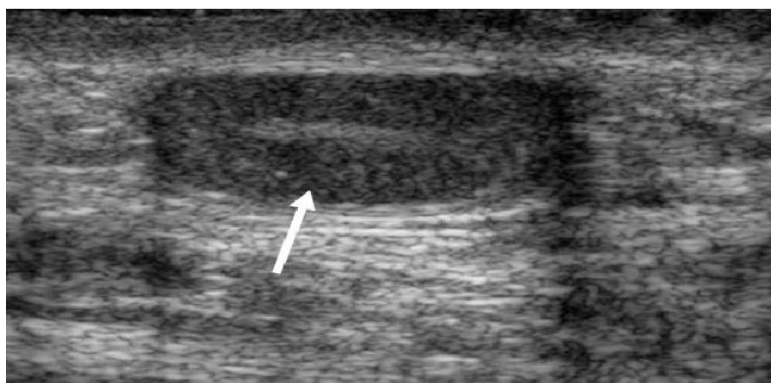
Ultrasonic imaging of a one-year-old boy with an undescended testis
